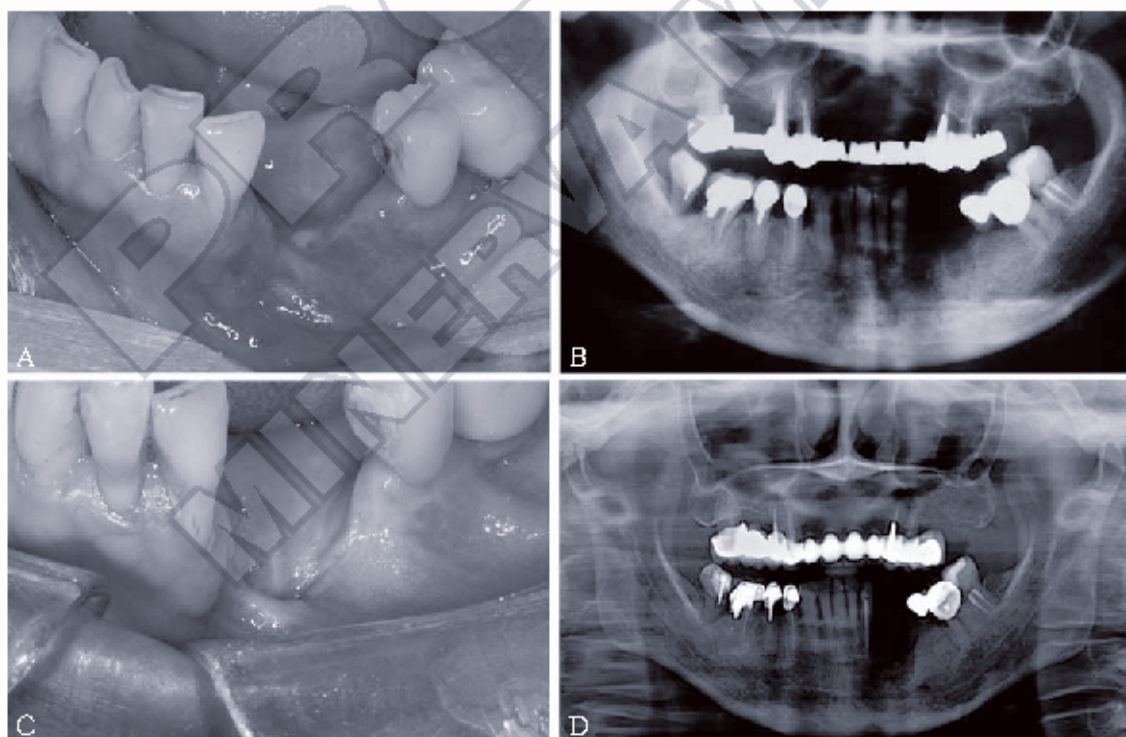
Case 2 (A) alveolar bone exposure in inferior first premolar region surrounded by an erythematous mucosa and suppurative secretion; (B) panoramic radiograph exhibited bone defect; (C) eighteen-month follow-up shows that mucosa healed properly; (D) panoramic radiograph after one year showed a regional bone defect, but without sequestration.
